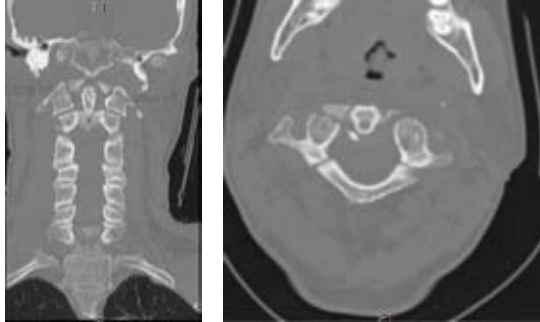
CT scan in the coronal plane reveals 12mm lateral mass separation, confirming the diagnosis of an unstable Jefferson fracture.
